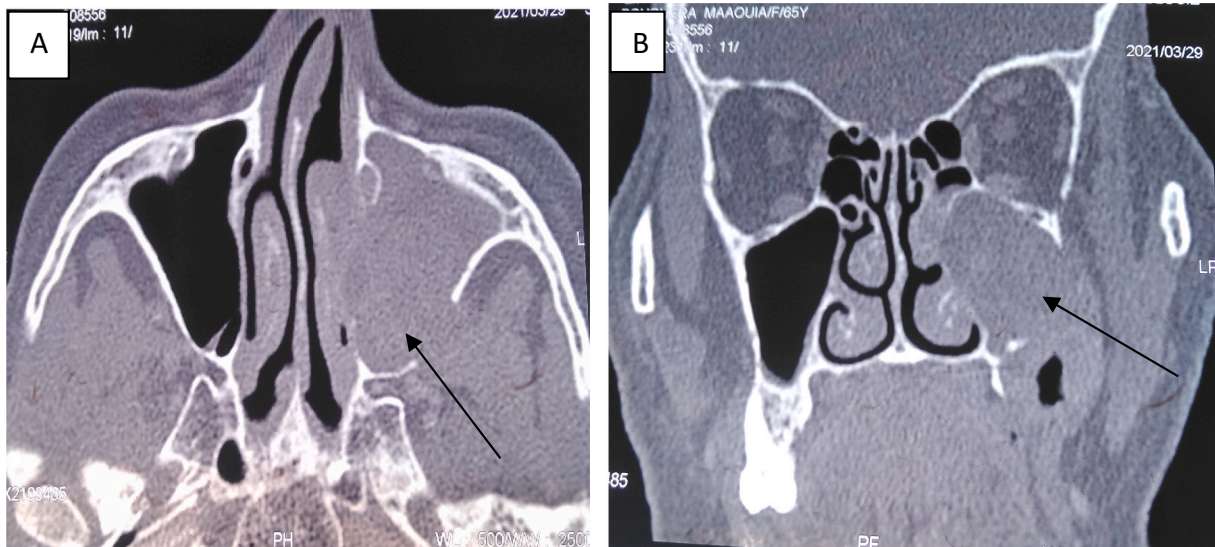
Preoperative axial (A) and coronary(B) CT scan with a tumorous mass in the left maxillary sinus spreading to infratemporal fossa.
